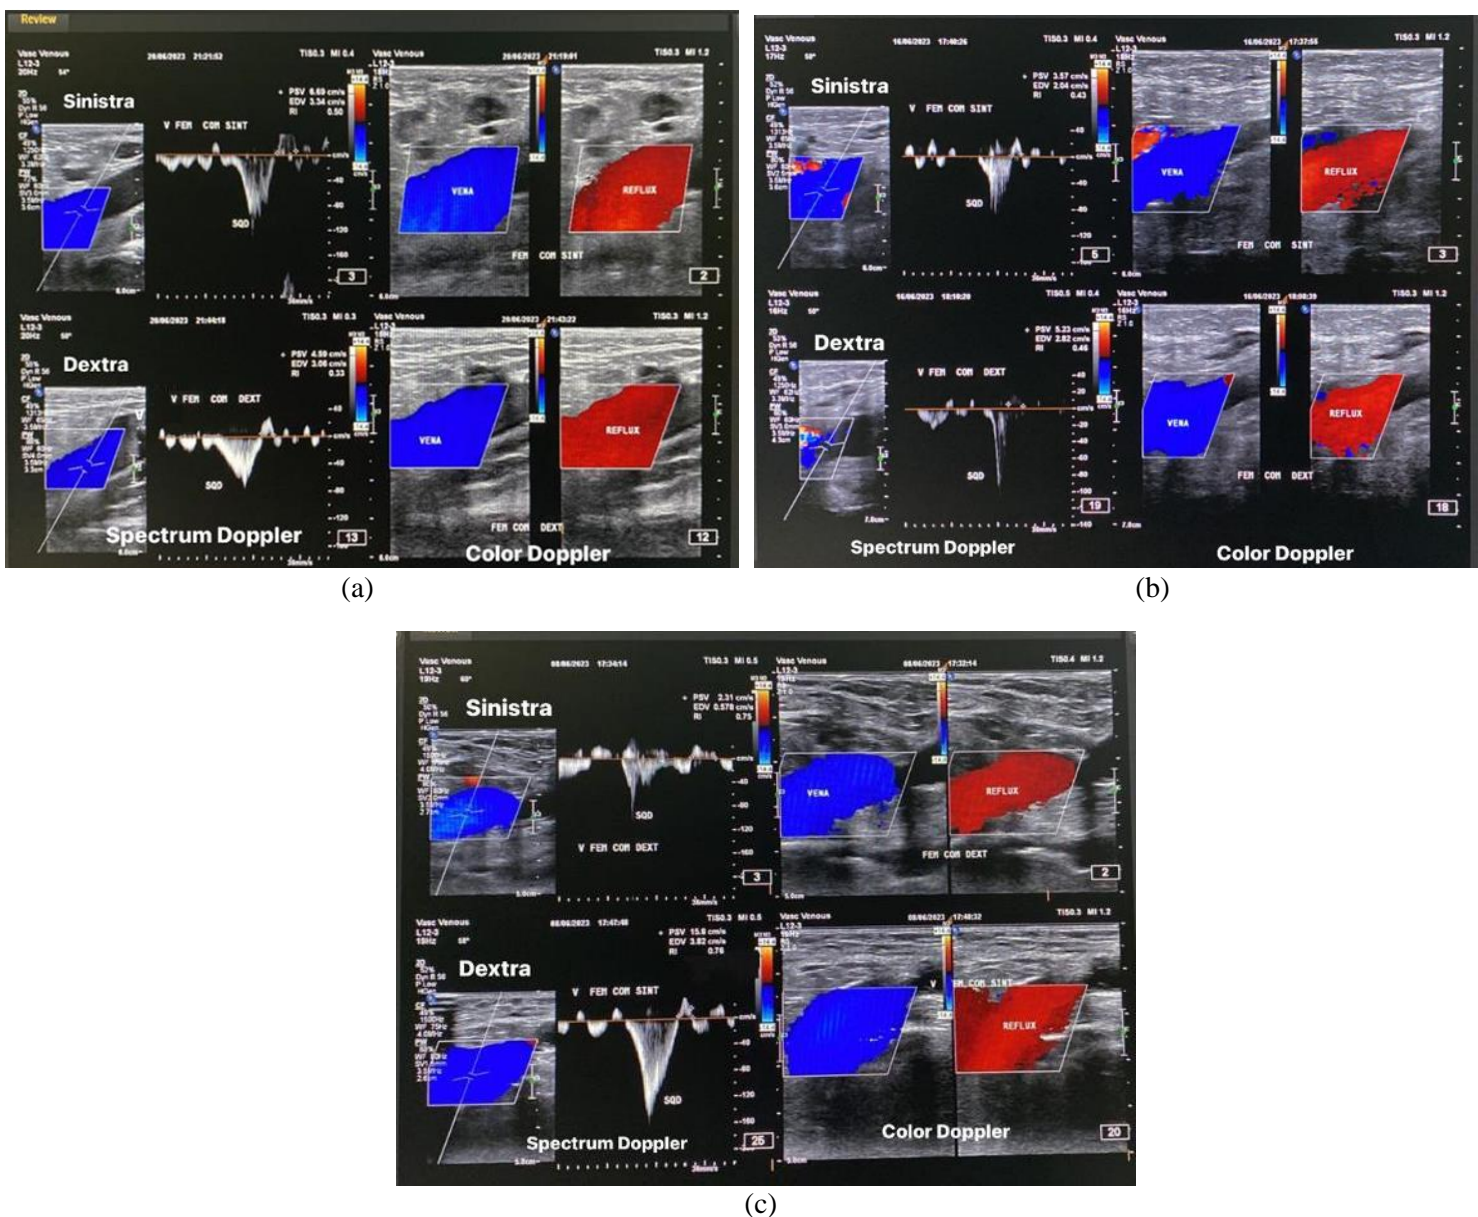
Description reflux on the doppler spectrum (*left*) and color doppler (*right*) from the dextra (*below*) and sinistra (*above*) femoral veins (a) Patient I, (b) Patient 2, and (c) Patient 3.
